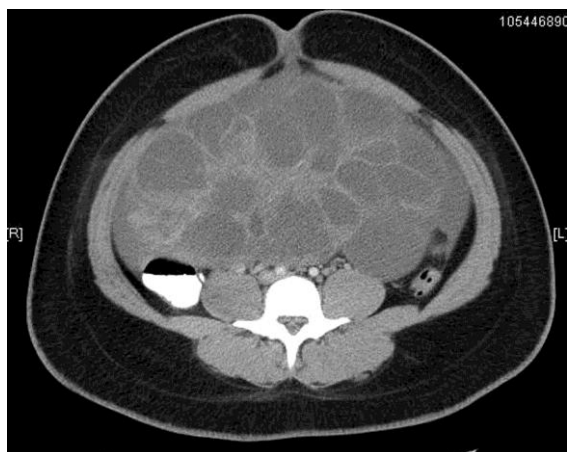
Contrast-enhanced coronal CT image demonstrating a large, multi-lobulated, low attenuation abdomino-pelvic mass.
